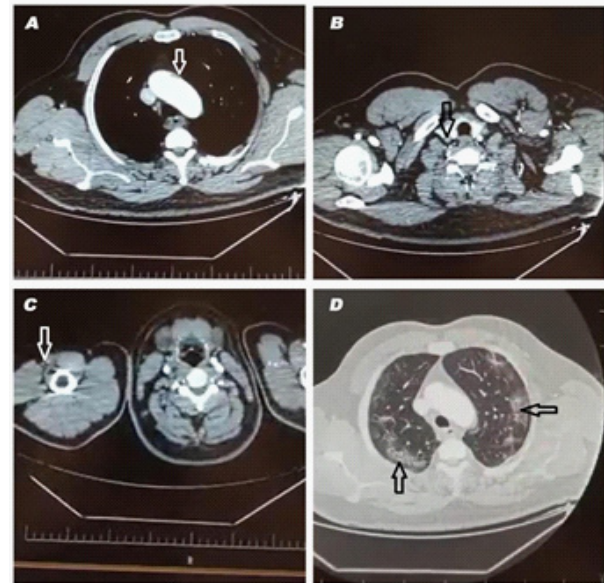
Contrast-enhanced computed tomography (CT) performed on a 48-year-old male. A, Plaque/thrombus at aortic arc (White arrow). B, Right common carotid artery thrombosis (Black arrow). C, Right brachial artery thrombosis (White arrow). D, Bilateral pneumonia as in Covid-19 (White arrows).
